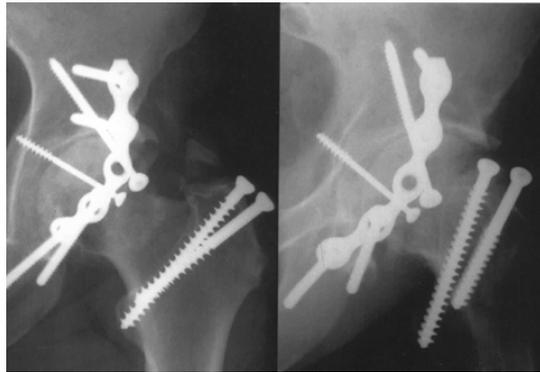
Radiographs taken 1-year after the operation showing hip joint narrowing and spur formation. Clinically, the patient shows moderate pain on ambulation and limitation of motion.
